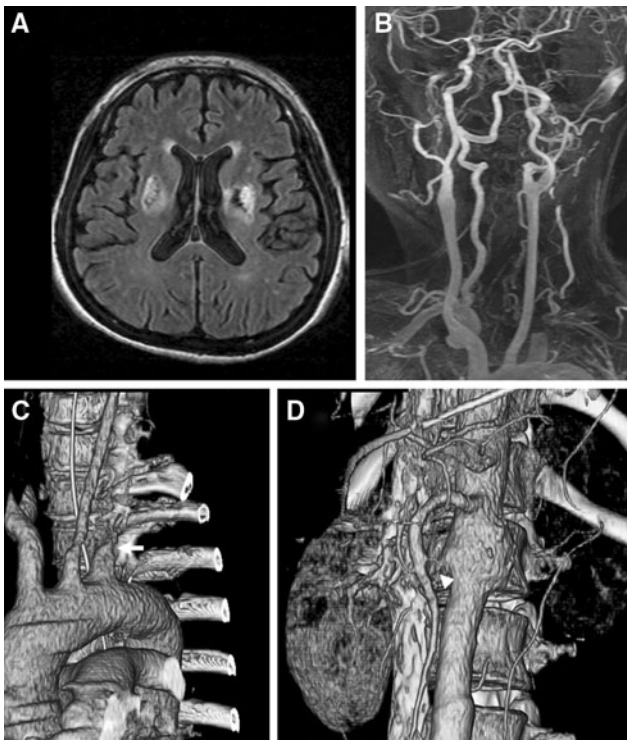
Case 1: magnetic resonance imaging (a, b) and three-dimensional computed tomography (c, d). FLAIR image and MRA reveal high-signal intensity at bilateral basal ganglia (a) and total obstruction of left subclavian artery (b). 3-D CT angiography showing total occlusion of left subclavian artery (c arrow), left renal artery and narrowing of right renal artery (arrow head) with mild aneurismal dilatation of abdominal aorta (d)
